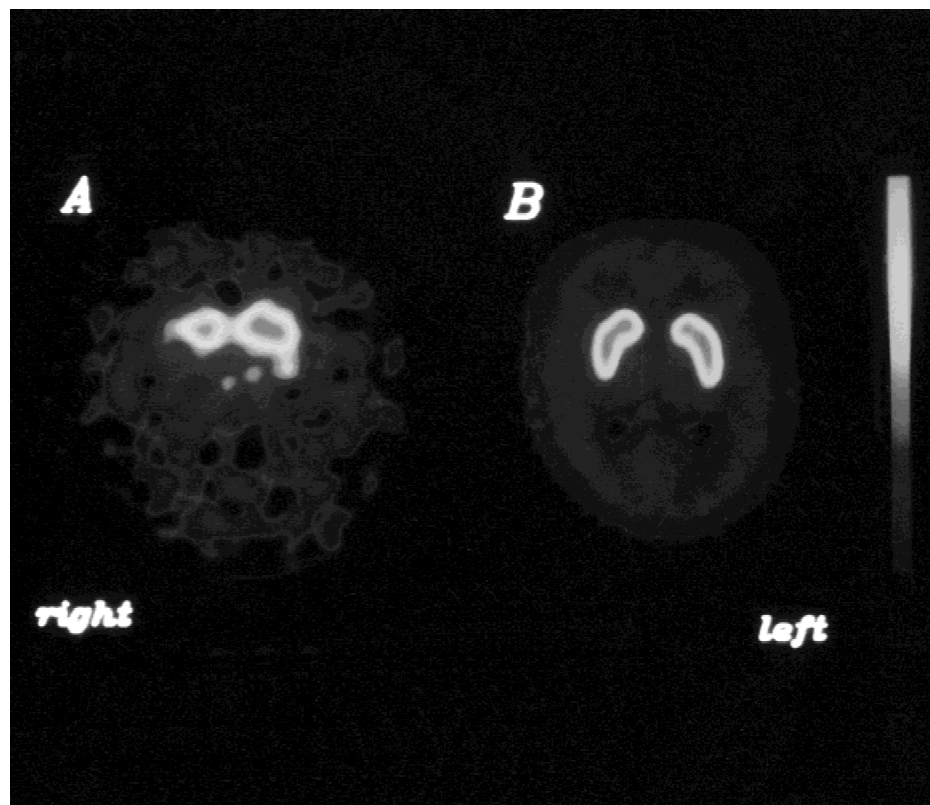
(A) [^{123}I]β-CIT SPECT detects a mild bilateral but asymmetric reduction of tracer uptake more marked in the putamen than in the caudate (see text). (B) [^{18}F]FESP PET demonstrates an intense and symmetric FESP uptake in both caudate nuclei and putamen.
